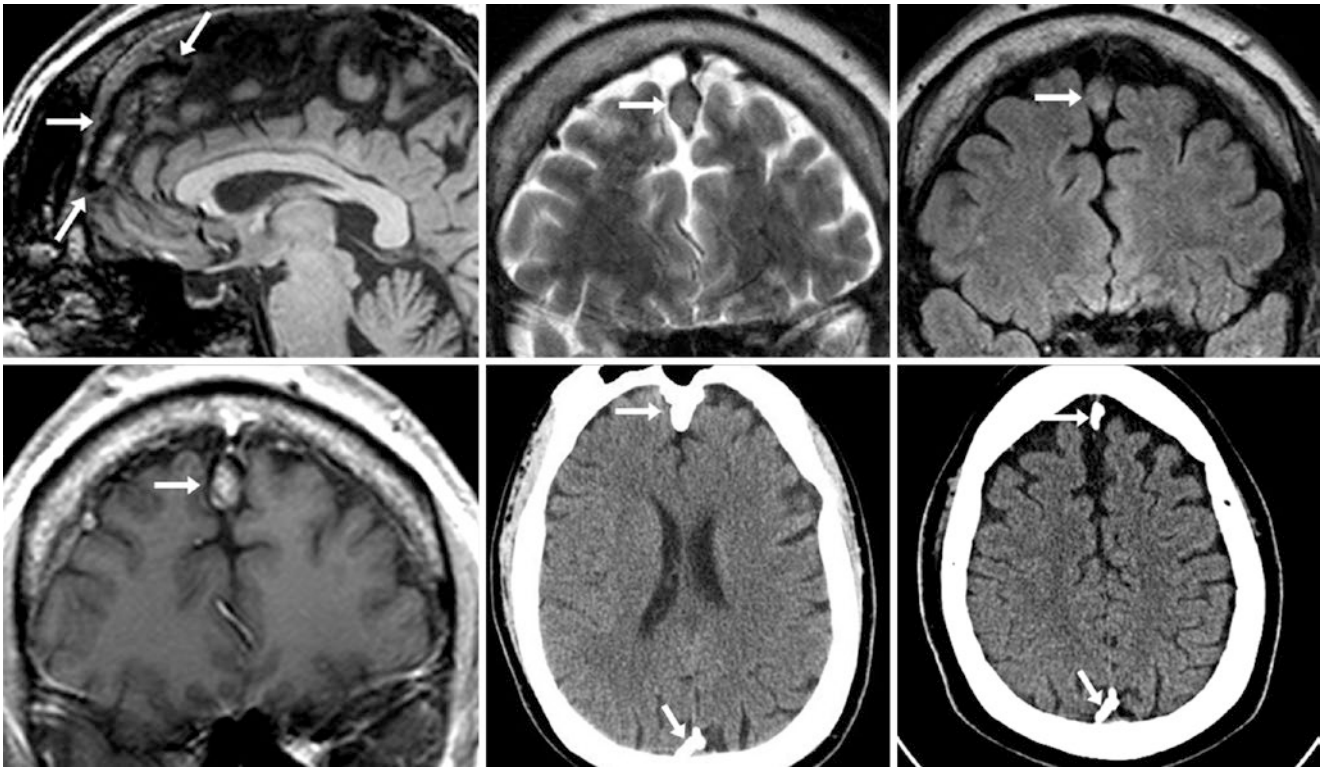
A 30 year old with a large, extra-axial lesion that is isointense (arrows) to gray matter as shown on a noncontrast 3T MRI with sagittal SE T1WI (top left), coronal T2WI (top middle), and FLAIR (top right). There is pseudo-enhancement on postcontrast SE T1WI
